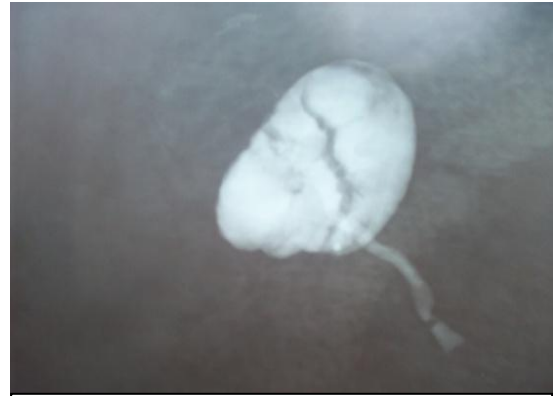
Radiograph of abruption placenta showing calcification
